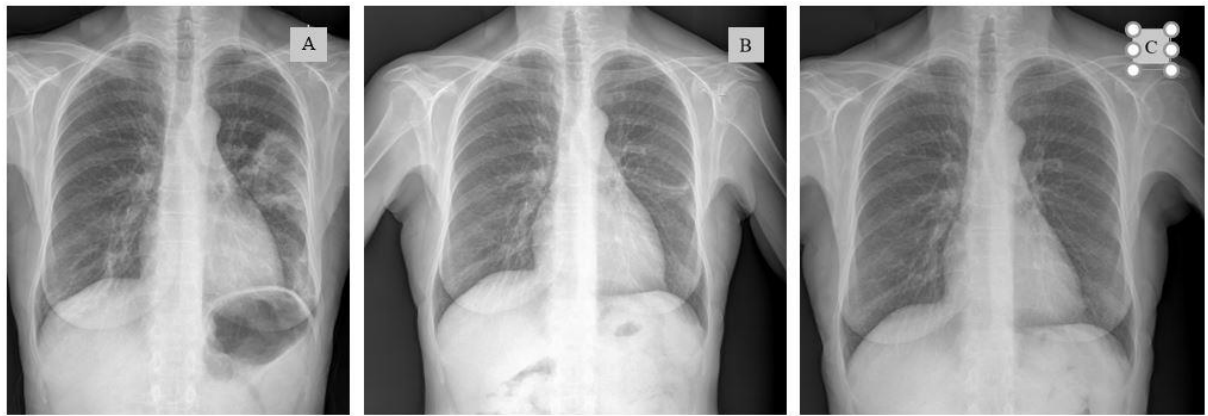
Chest radiographs from patient Case No. 2, before administrating corticosteroid therapy (A), one month after corticosteroid treatment started (B), and one year after starting treatment of COP (C)
